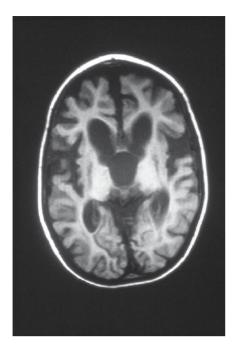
AA: CT scan of the brain. There was considerable atrophy. Progression of disease was documented [16] in a woman who demonstrated only retinitis pigmentation and mild sensory neuropathy by the age of 39 and was otherwise clinically normal. At the age of 59 she was blind, diabetic, and had sensorineural hearing loss.
